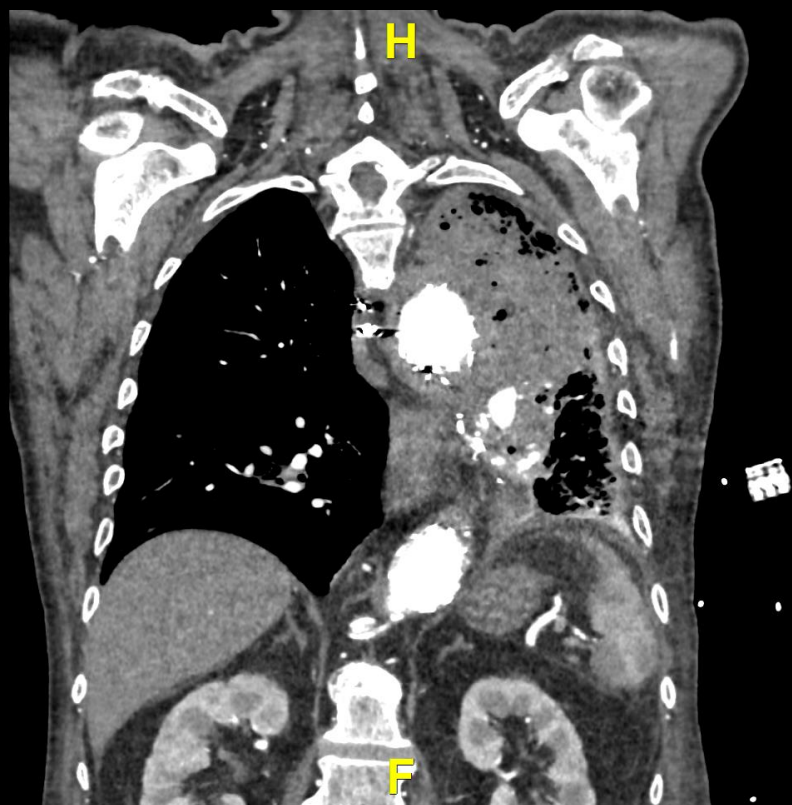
a, b. Esophagogastroduodenoscopy (a) and CT (b) images of the aortoesophageal fistula detected air bubbles around the stent graft in the aneurysm sac of the descending thoracic aorta (b, white arrow). The precise fistula site was not visible, but no contact between the stent graft and the fistula was observed. A fistula without any bleeding was seen at the inner surface of the mid-esophagus (a, black arrow).
